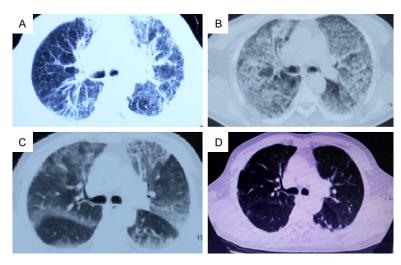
Serial CT thorax scans of a 58-year-old man who presented with fever and hemoptysis, A: CT scan showed high-density opacities involving both lung fields on August 6th, 2015, two days before admission; B: CT scan showed high-density opacities involving both lung fields progressed fast compared with A in just two days; C: CT scan showed diffuse high-density shadow improved significantly after timely and correct treatment of 1 week; D: CT scan showed a near normal image with minimal localized interstitial shadows on the left side at half-month after discharge.
